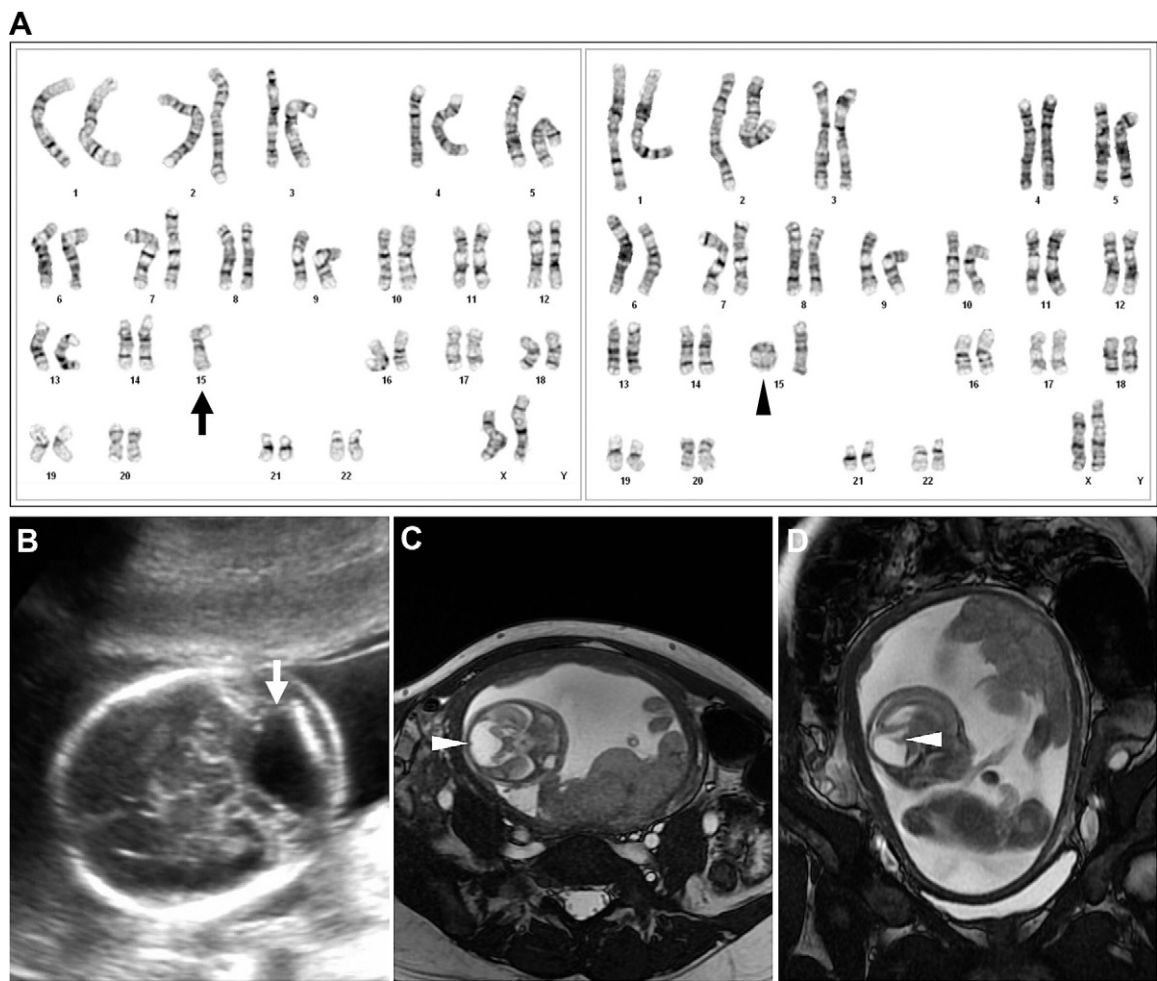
(A) Karyotype: monosomy 15 (arrow) and ring chromosome 15 (arrowhead). (B) Transabdominal sonography shows a posterior fossa cyst (arrow). (C) MRI (axial plane) of fetal head reveals a hypoplastic cerebellum lying anteriorly and laterally of a markedly dilated fourth ventricle (arrowhead). (D) MRI (sagittal plane) of the fetal head discloses a small rudimentary superior vermis (arrowhead). The inferior vermis was not formed. MRI = magnetic resonance imaging.
